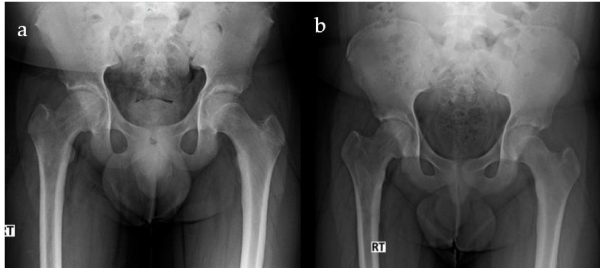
Follow-up radiographs one month after screw removal and physeal closure showing notable remodeling of the femoral neck and improvement in morphology.
